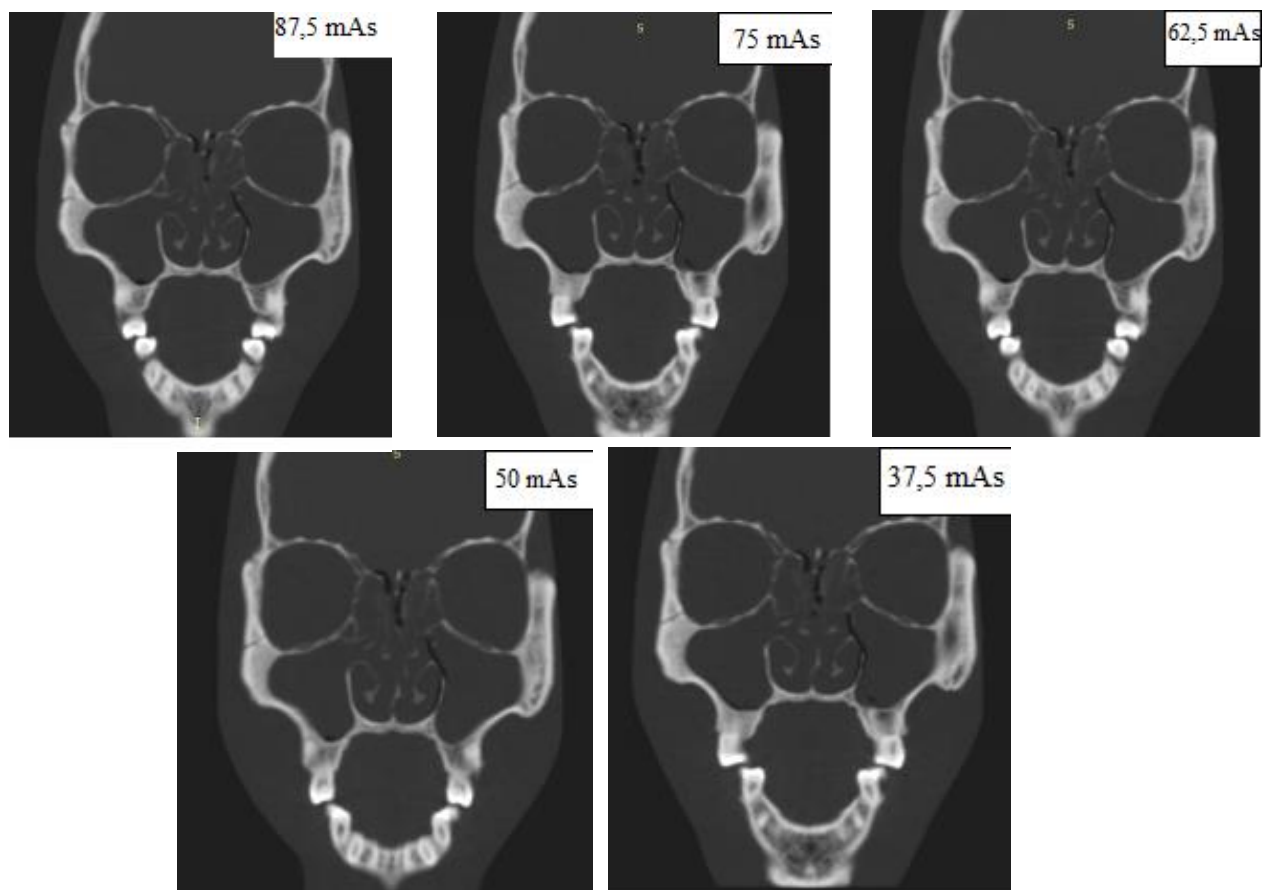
Variation of mAs on CT scan of facial bone with ASIR 60%
